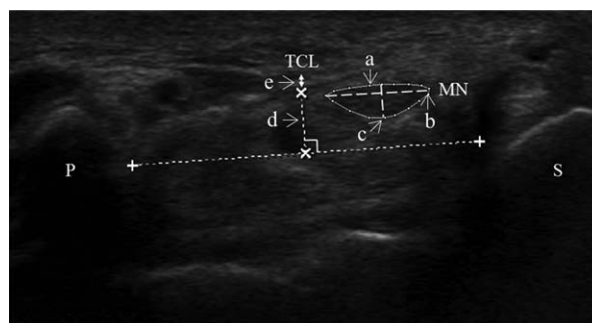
Measurements of the ultrasound parameters. Cross-sectional area of the median nerve (a), major axis length (b) and minor axis length (c) of the median nerve, palmar bowing of the transverse carpal ligament (d), and thickness of the transverse carpal ligament (e). MN, median nerve; TCL, transverse carpal ligament. Bony landmarks are P, pisiform; S, scaphoid.
